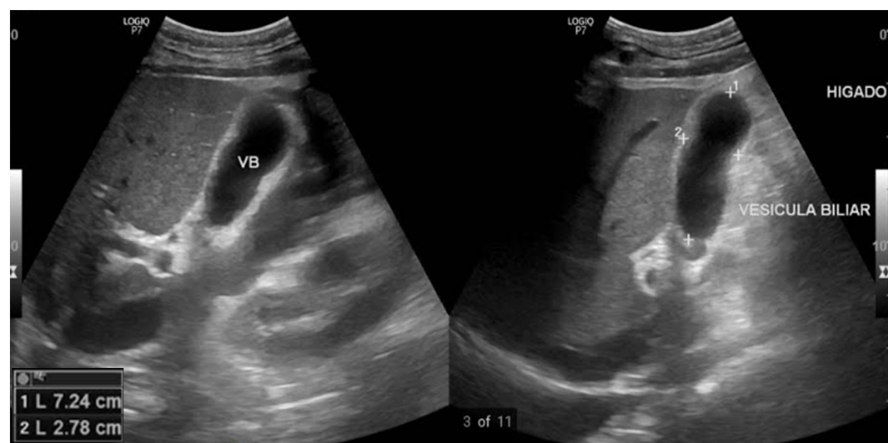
Upper abdominal ultrasound. Chronic acalculous cholecystitis, thickening of the wall, with echogenic material inside, without posterior acoustic shadow, compatible with biliary sludge.
